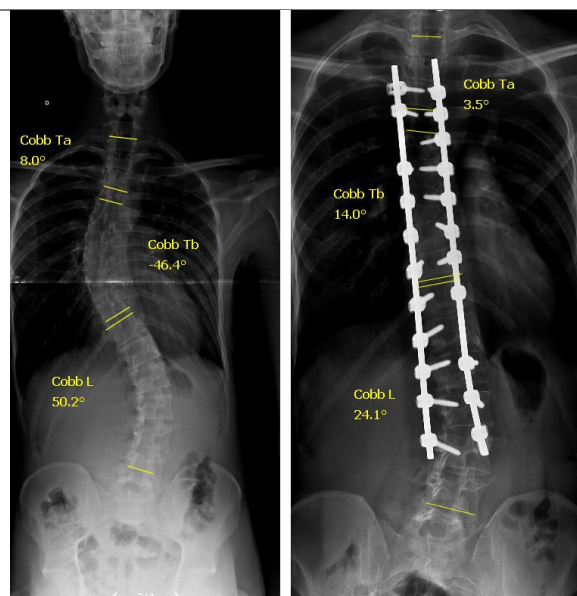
Representation of the improvement of radiographic parameters of the Cobb Angle proximal Thoracic (Cobb Ta), Cobb Angle distal Thoracic (Cobb Tb) and Cobb Angle Lumbar (Cobb L).
